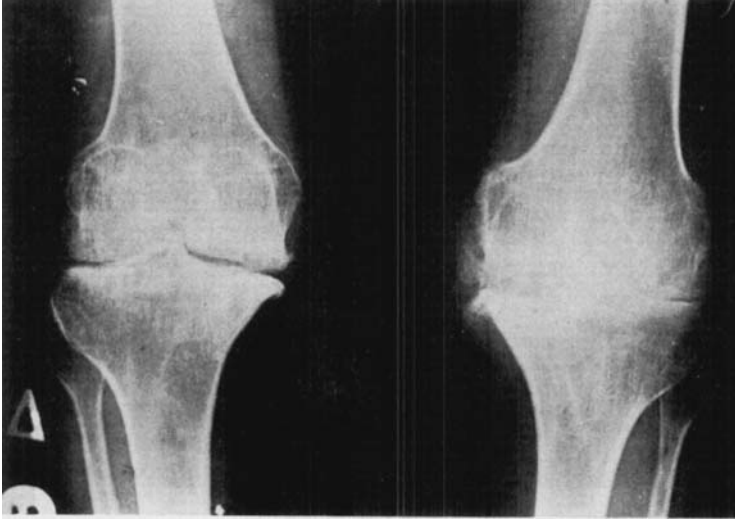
Radiographs of the same patient.
